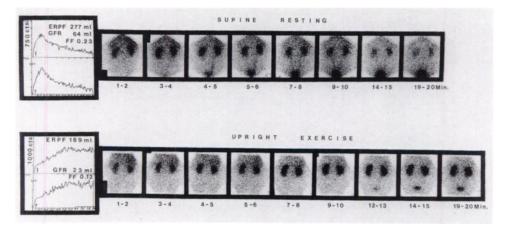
Renogram and sequential scintigrams of a 45-yr-old hypertensive male patient (no. 12) with angiographically documented unilateral vascular stenosis, examined in supine position and during upright exercise. The sequence of examinations demonstrate the exercise induced changein transrenal o-iodohippurate transport. The supine examination documents timely hippurate excretion from renal tissue, as evidenced by time-activity curves, tracer excretion into the bladder during the 4th minute and hippurate washout from the tissue of both kidneys towards the end of the examination. Exercise initiated a massive disturbance of tracer kinetics: the transport abnormality is at the parenchymal level. Note the clearance data, obtained during 25 watt ergometric exercise, which demonstrate that the hippurate transport disturbance is associated with a reduced ERPF and GFR, as well as a reduced FF.
